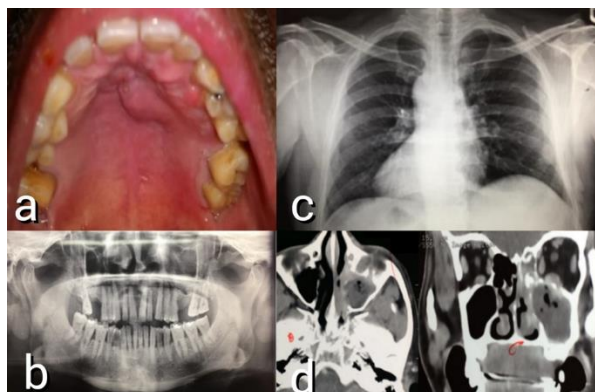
a. Intraoral image showing multiple draining sinus b. orthopantomogram c. PA chest d. CT images.
